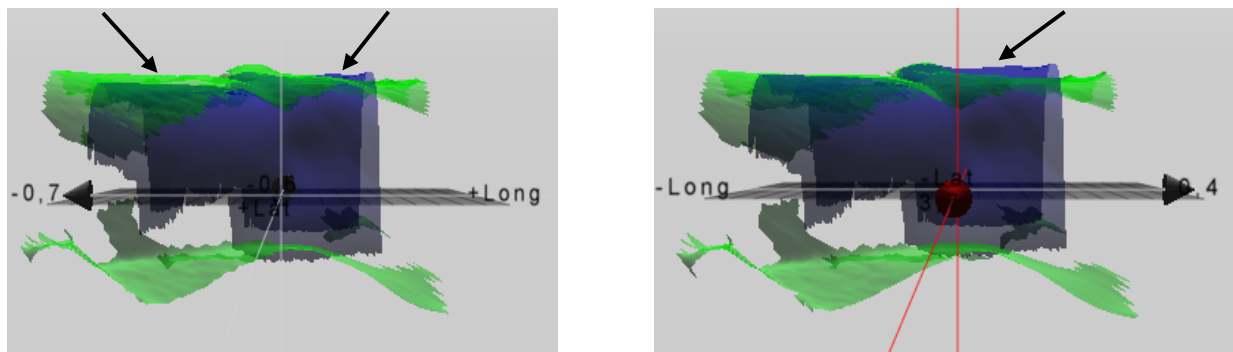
Reference surface in blur and live surface in green. Figure to the left shows patient setup according to the Catalyst™ and to the right, after corrected setup according to the CBCT
